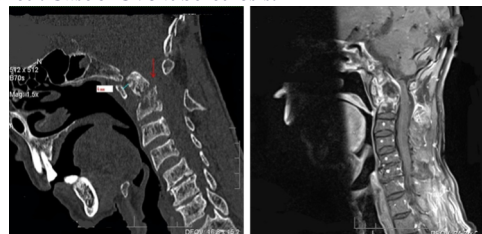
(a) flexion mid sagittal CT Figure 9(b) post contrast T1 mid sagittal images
